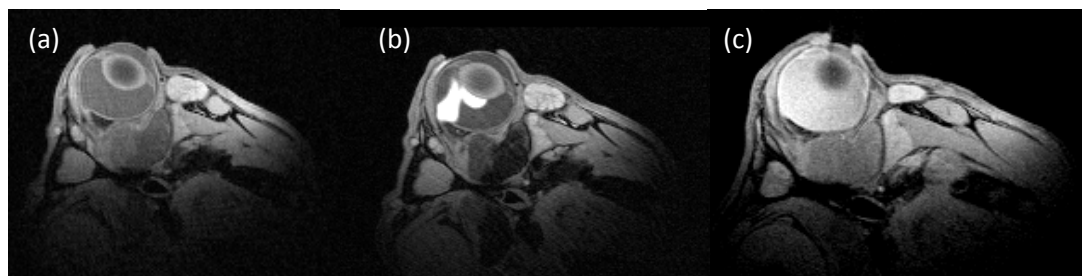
^1H MR images (a) right before, (b) immediately and (c) 5 hours after the intravitreal injection. The bright region in (b) indicates the initial location of the TAP/MnEDTA/saline solution.
